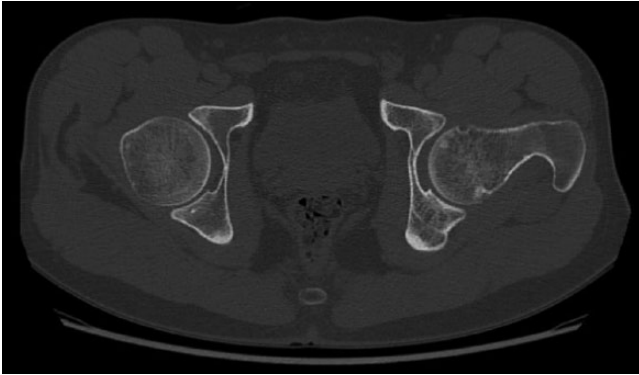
CT of the hip: the small erosions like at the femoral neck.
